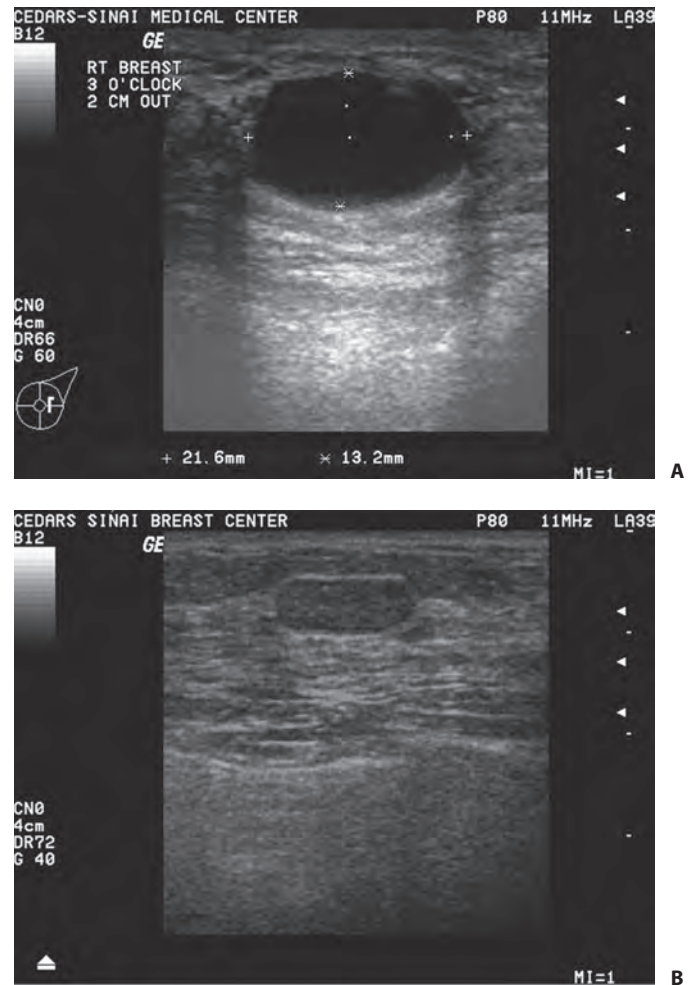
A: Ultrasound demonstrating a simple cyst. B: Ultrasound demonstrating a solid mass.
